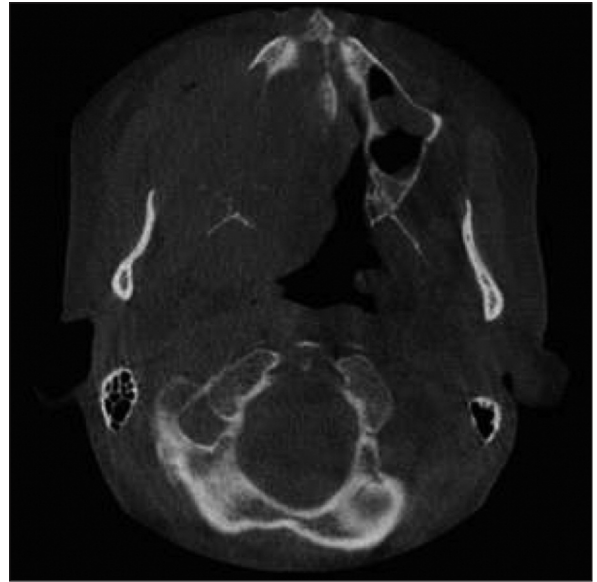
Axial section on cone beam computed tomography showing destruction of right maxilla.
